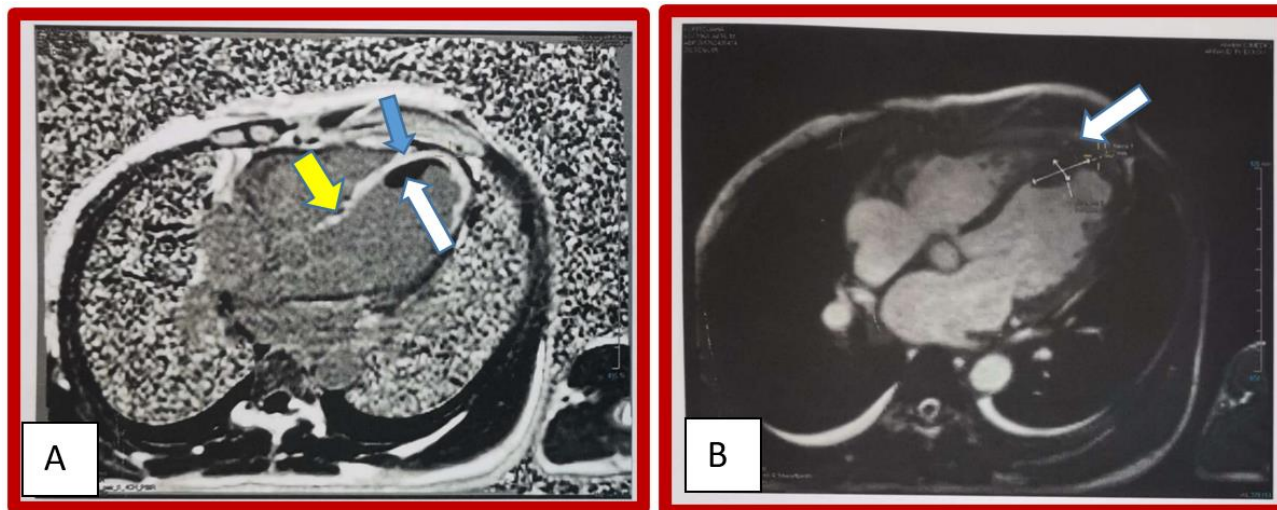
Cardiac magnetic resonance imaging which highlights in picture A, an ischemic model with subendocardial contrast uptake with transmural extension (blue arrow) and no-reflow (yellow arrow) and in picture B, a thrombus in the septal apical position (white arrows).
